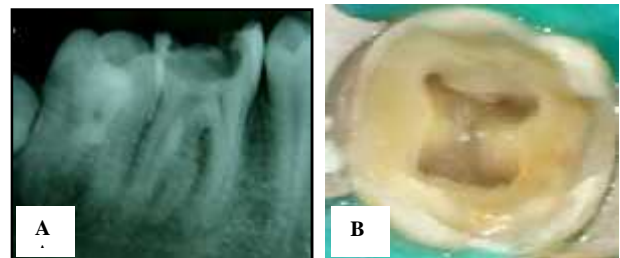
(a) Pre-operative radiograph (b) Intraoral photograph revealing 4 canals
